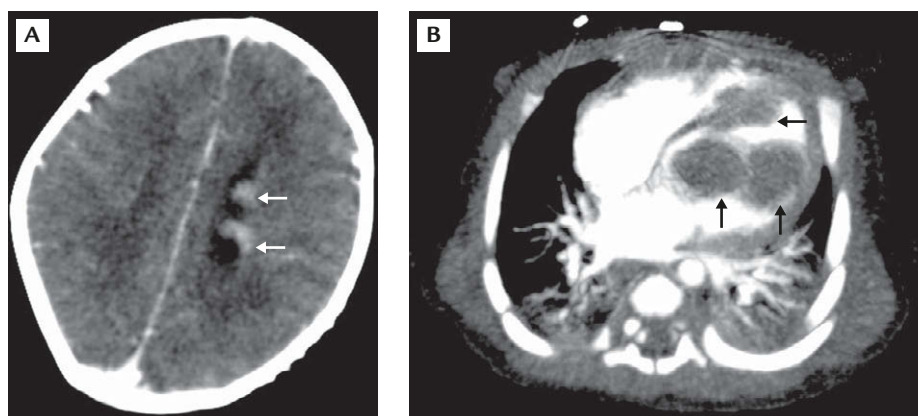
Neonatal computed tomography scan of the affected infant demonstrating (A) subependymal tubers and (B) intracardiac rhabdomyomas in the left ventricle.
